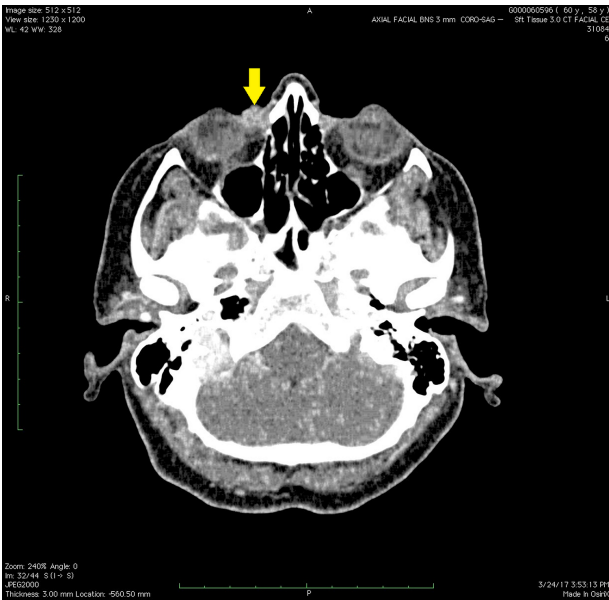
A non-contrast CT scan showing a well-circumscribed hyperintense circular area in the right medial canthal preseptal area.
